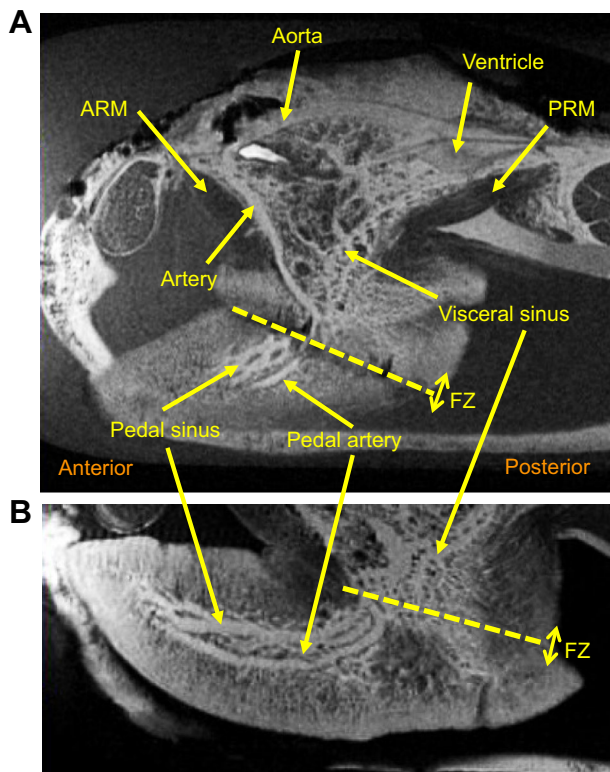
Vascular structure of the foot of a living *C. okutanii* measured by T_{1w} -MRI. The clam was incubated in 1 mmol l^{-1} GdDTPA seawater for 1.5 days. (A) Mid-sagittal image of a living clam. (B) Mid-sagittal image of the foot. Vessels appear white. The dashed yellow lines indicate the direction of the FZ.
